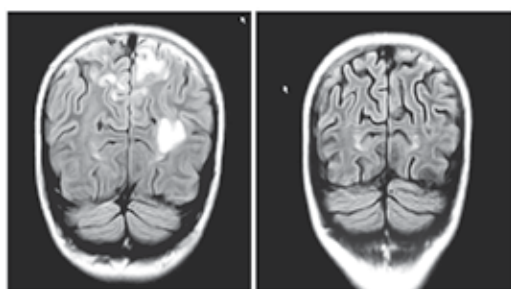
Posterior Reversible Encephalopathy*: MR imaging, Coronal T2 FLAIR, of a child with AL treated with vincristine that developed headache, hypertension and seizures. Left panel shows white matter hyperintensity in both hemispheres. After 18 days (right panel) these signs were inappreciable.
